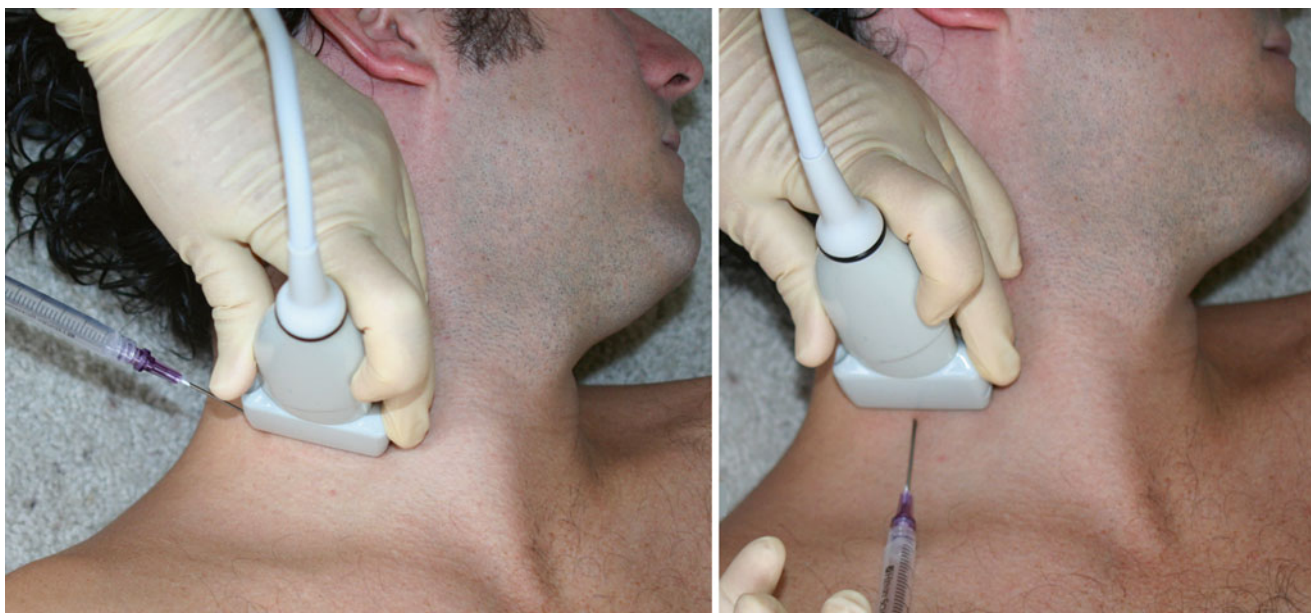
Ultrasound-guided injection of the long thoracic nerve at the middle scalene muscle, showing in-plane (image a) and out-of-plane (image b) approach (Image courtesy of Andrea Trescot, MD)
